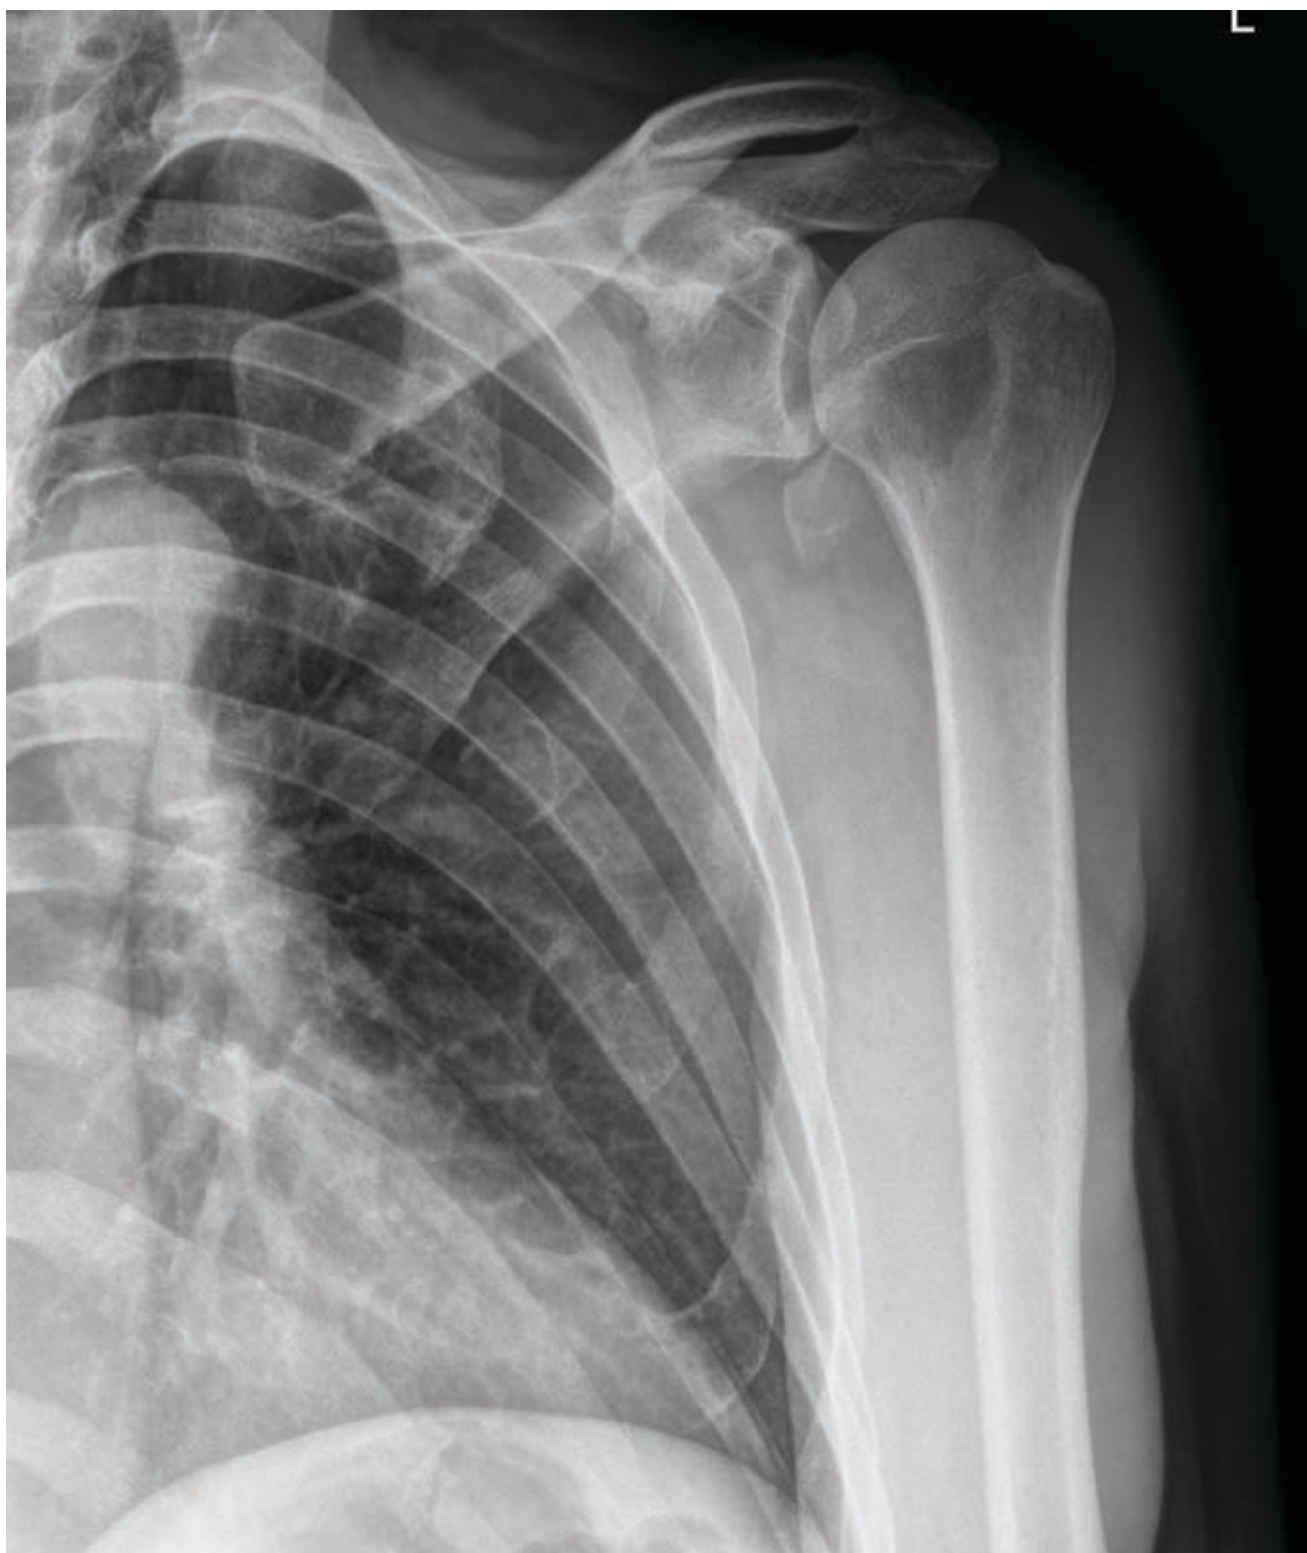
Anteroposterior radiograph of the left shoulder shows the displaced lesser tuberosity
